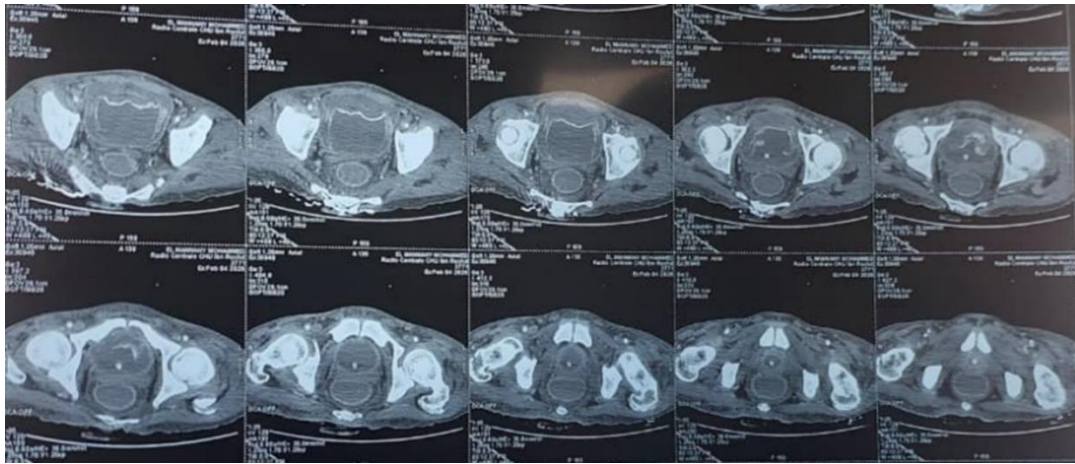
Abdominopelvic CT scan showing a markedly thickened and heterogeneous bladder wall with a necrotic appearance
